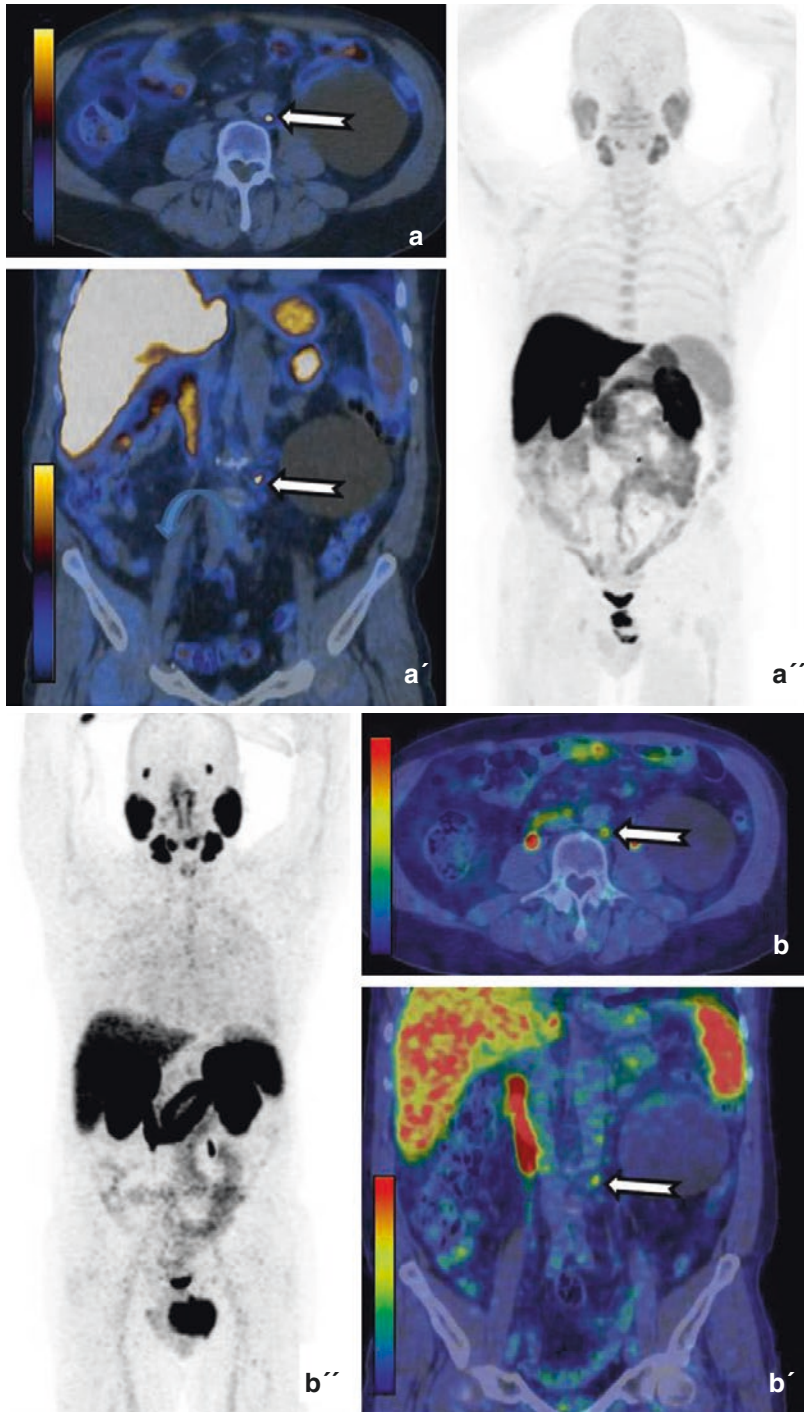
This figure displays a 64-year-old patient, during early biochemical relapse (PSA 0.3 ng/mL) 1 year after radical prostatectomy for prostate cancer; patient was examined with ^{18}F -FMC and ^{68}Ga -PSMA PET/CT. Axial (a) and coronal (a') ^{18}F -FMC PET/CT views show pathologic tracer uptake in a single para-aortic lymph node (arrows), also evident in ^{18}F -FMC PET maximum intensity
